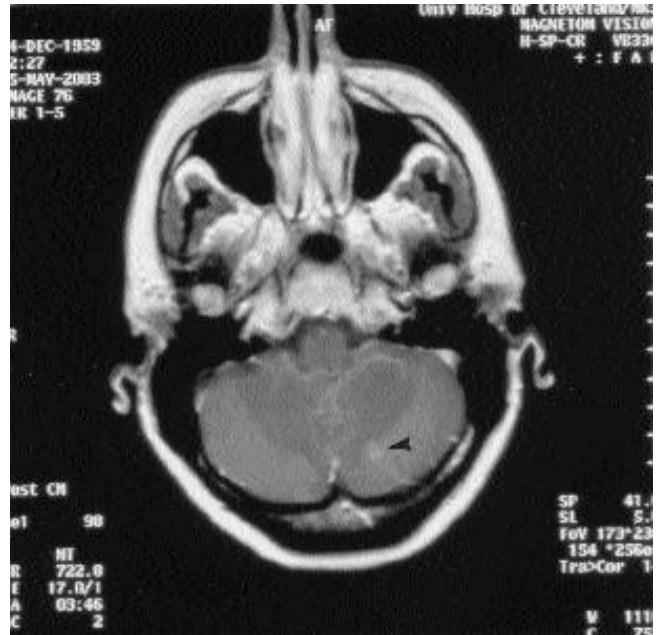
Arrow points to area of increased signal in the cerebellum on MRI 6 days into the illness. The lesion was not present on initial MRI.
